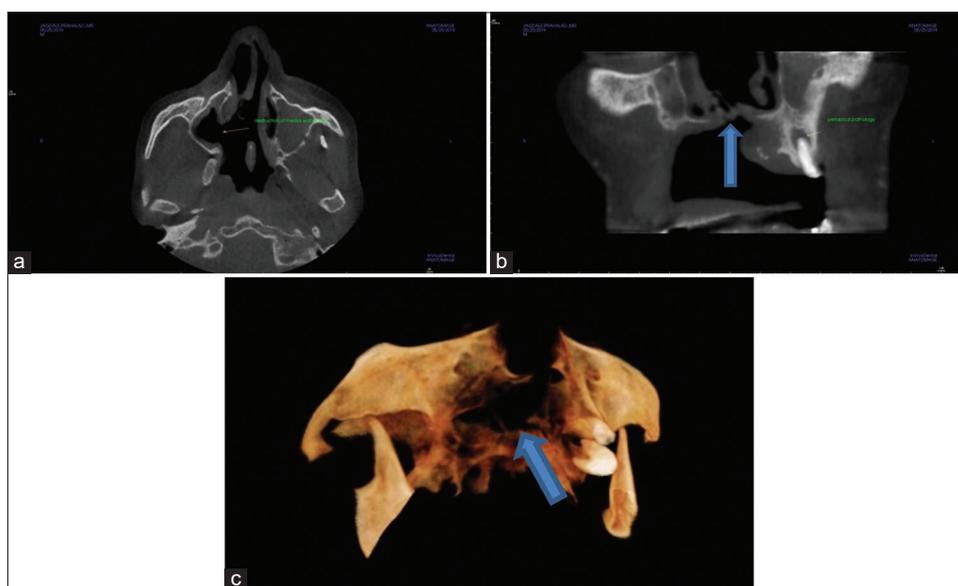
(a) Axial section of cone-beam computed tomography (CBCT) showing invasion of lesion superiorly and posteriorly causing destruction of medial wall of the right maxillary sinus, (b) coronal section of CBCT showing destruction of nasal floor, and (c) volume render in CBCT-showing extensive involvement of maxilla and nasal floor
